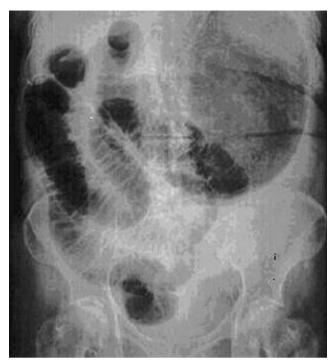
Preoperative plain abdominal X-ray
